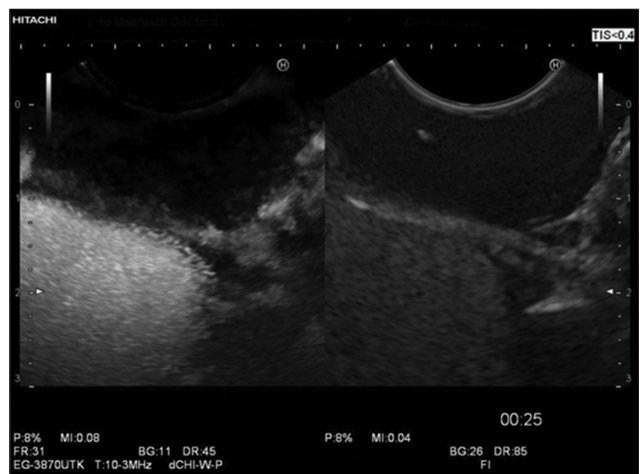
Under contrast-enhanced endoscopic ultrasound, leiomyomas typically present as hypoenhanced tumors
